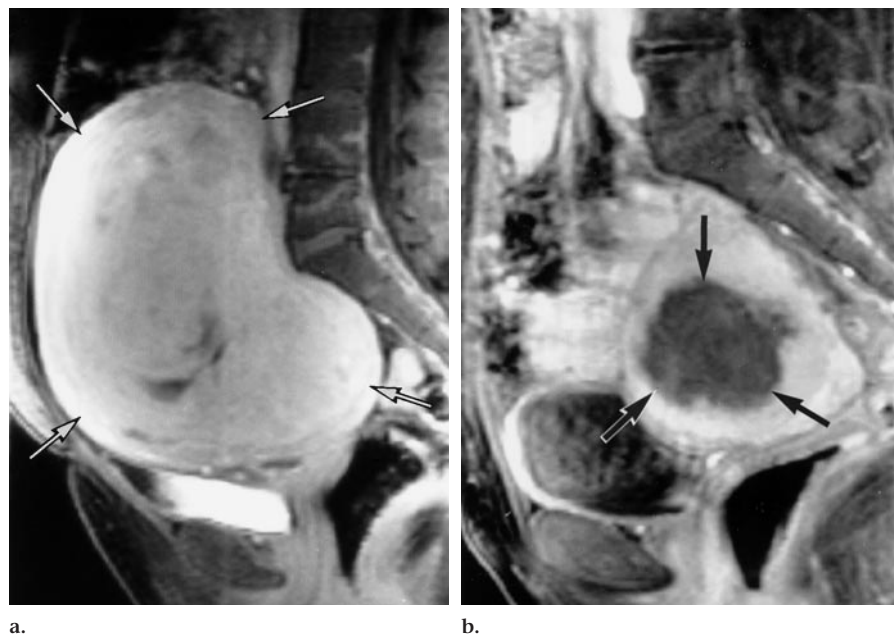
Sagittal T1-weighted gadolinium-enhanced two-dimensional fast low-angle shot MR images (180/4.8, 75° flip angle, 256 × 106 matrix, 300 × 300-mm field of view, 8-mm-thick sections). (a) Before embolization, fibroleiomyoma (arrows) enhancement is equivalent to that of the surrounding myometrium. (b) After embolization, the fibroleiomyoma (arrows) is no longer enhancing.
